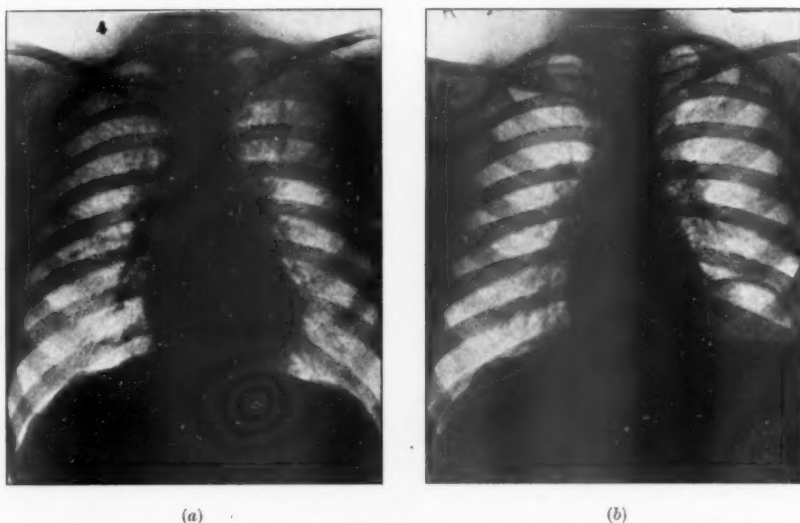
a* and *b*.—Adult male. (Dr. Lloyd's case.) Large cavity in the left upper lobe, where pneumothorax was attempted and failed. Later phrenic avulsion was performed by Mr. Price Thomas, and at present the cavity cannot be recognized in the plain X-ray film.
